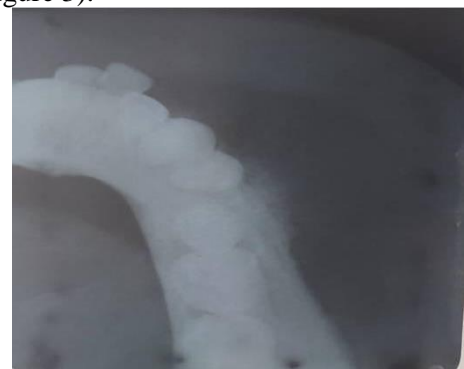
Occlusal radiograph of the lesion present in the left body of the mandible
